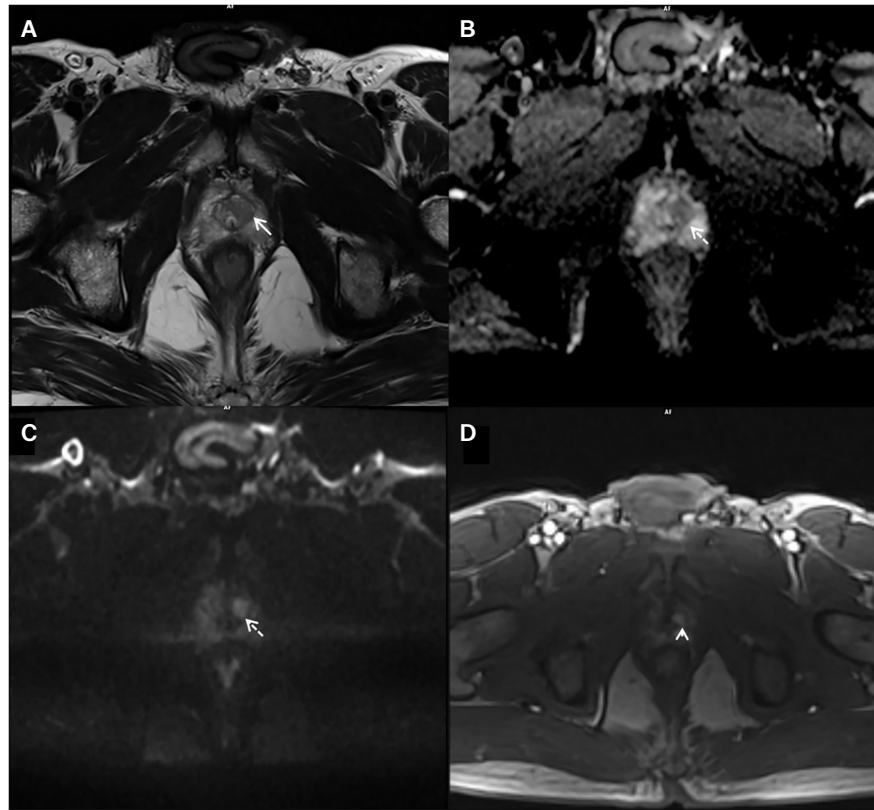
(A) Axial T2-weighted image shows a circumscribed hypointense atypical nodule in the anterior aspect of left apex transitional zone (arrow). (B) Apparent diffusion coefficient map shows marked hypointensity in the lesion compared to the background (dashed arrow) and (C) diffusion weighted images (DWI) ($b=1500 \text{ s/mm}^2$) show marked hyperintensity in the lesion compared to the background (dashed arrow), respectively. (D) Dynamic contrast-enhanced image shows early contrast enhancement in the nodule (arrowhead) (T2 score: 2, DWI score: 4, dynamic contrast-MRI: positive, Prostate Imaging Reporting and Data System category 2 + 1).
